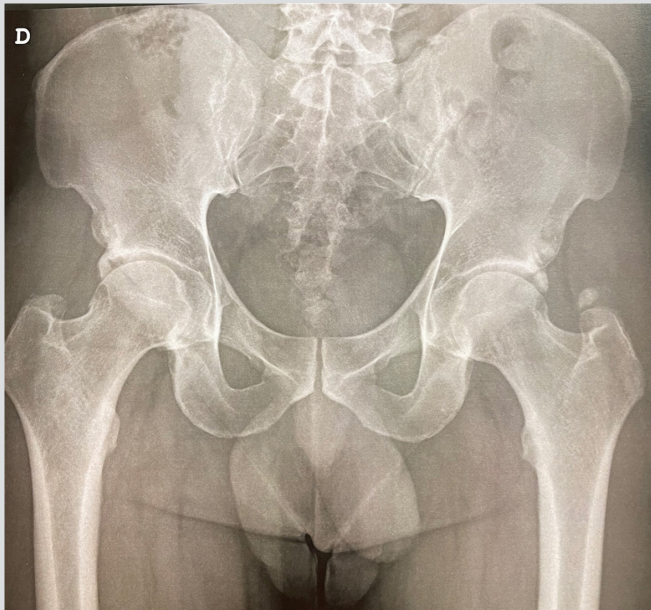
Plain X-ray of the sacroiliac joints showing signs of sacroiliitis grade 2
